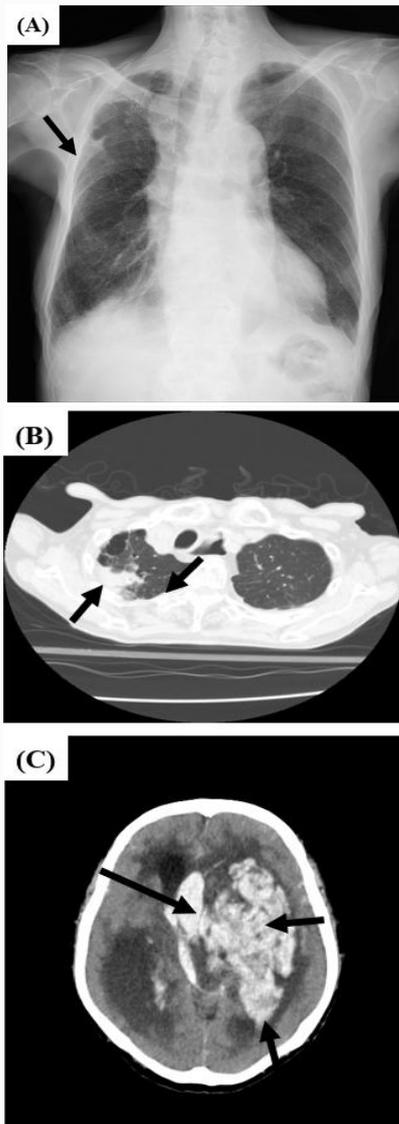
Chest X-ray (A), CT (B), and brain CT (C) of the case 2 patient on admission. Infiltration shadow is found in his right upper lung field (A and B). On day 6, massive brain hemorrhage has suddenly developed (C). Arrows indicate the abnormal shadows on chest X-ray, CT, and brain CT, such as infiltration shadows in the lungs and hemorrhage in the brain.
